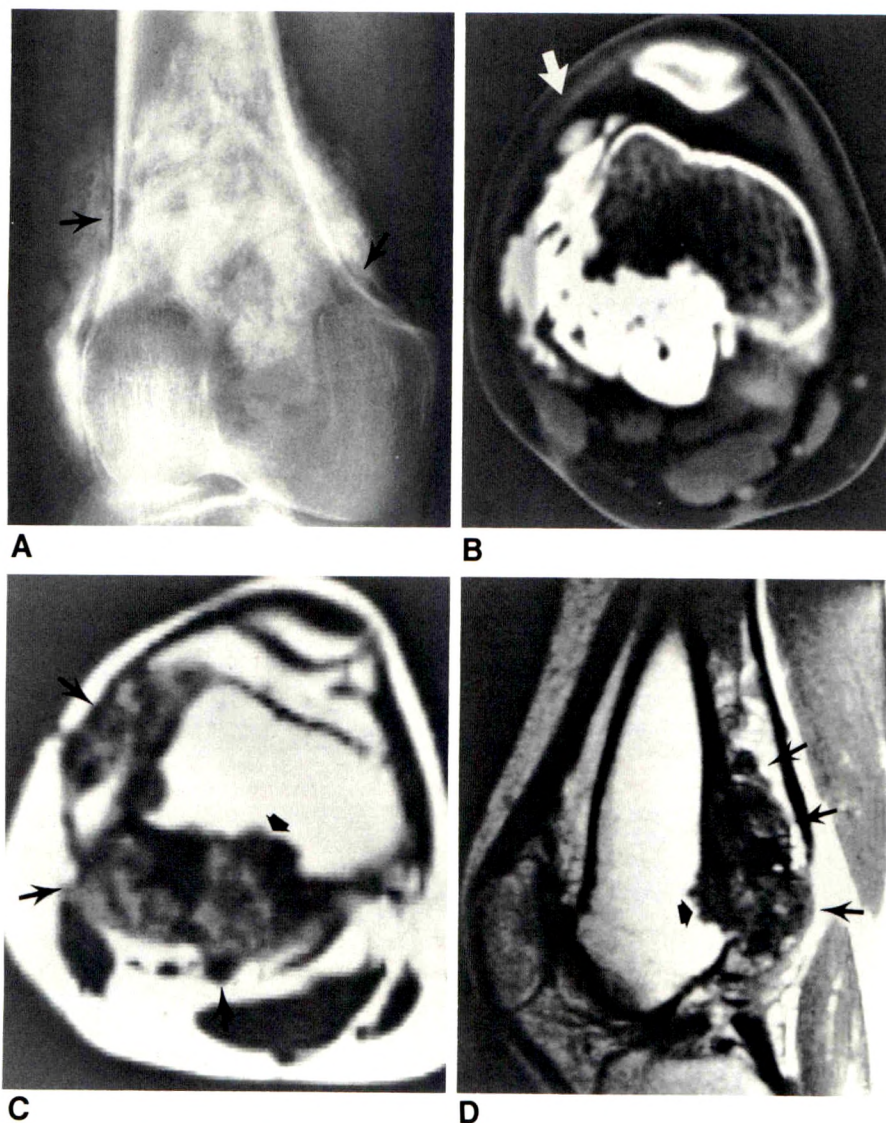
A, Anteroposterior radiograph shows parosteal osteosarcoma of distal femur to be ossified and enveloping bone. Radiolucent cleavage planes (arrows) between normal cortex and neoplasm.
